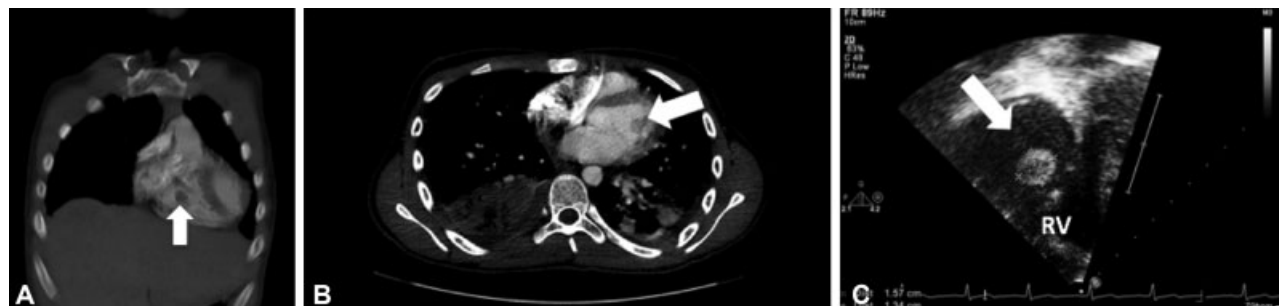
(A) Coronal and (B) axial computed tomography angiography demonstrates right ventricular mass/vegetation (large white arrow); (C) transthoracic echocardiogram demonstrating mobile circular mass in the right ventricle (arrow), attached to the chordae of the tricuspid leaflets.
